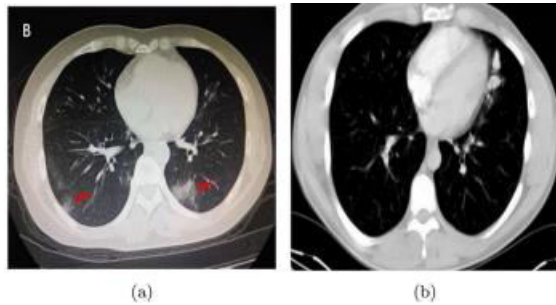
Lung CT-scan images a COVID-19 affected, b normal
